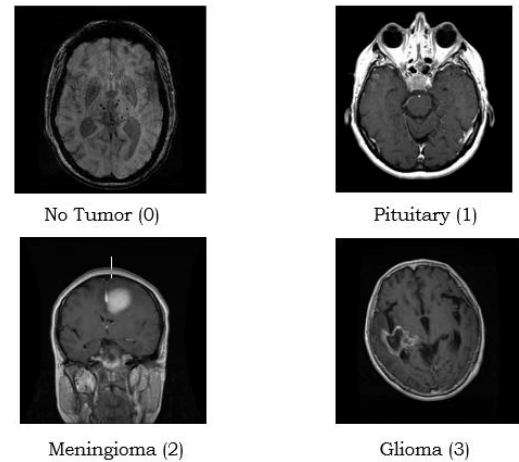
Example of an MRI image of the brain
